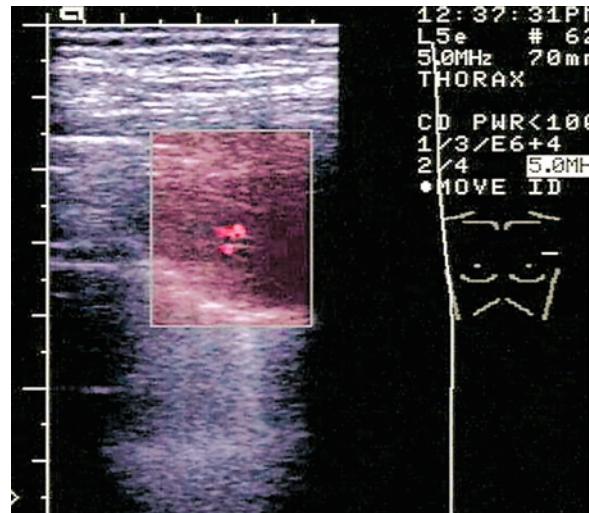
A small hypoechoic lesion in a 78-year-old man: an incidental finding in the upper lobe of the left lung, in infra-clavicular location. Sonography-guided biopsy indicated squamous cell carcinoma
